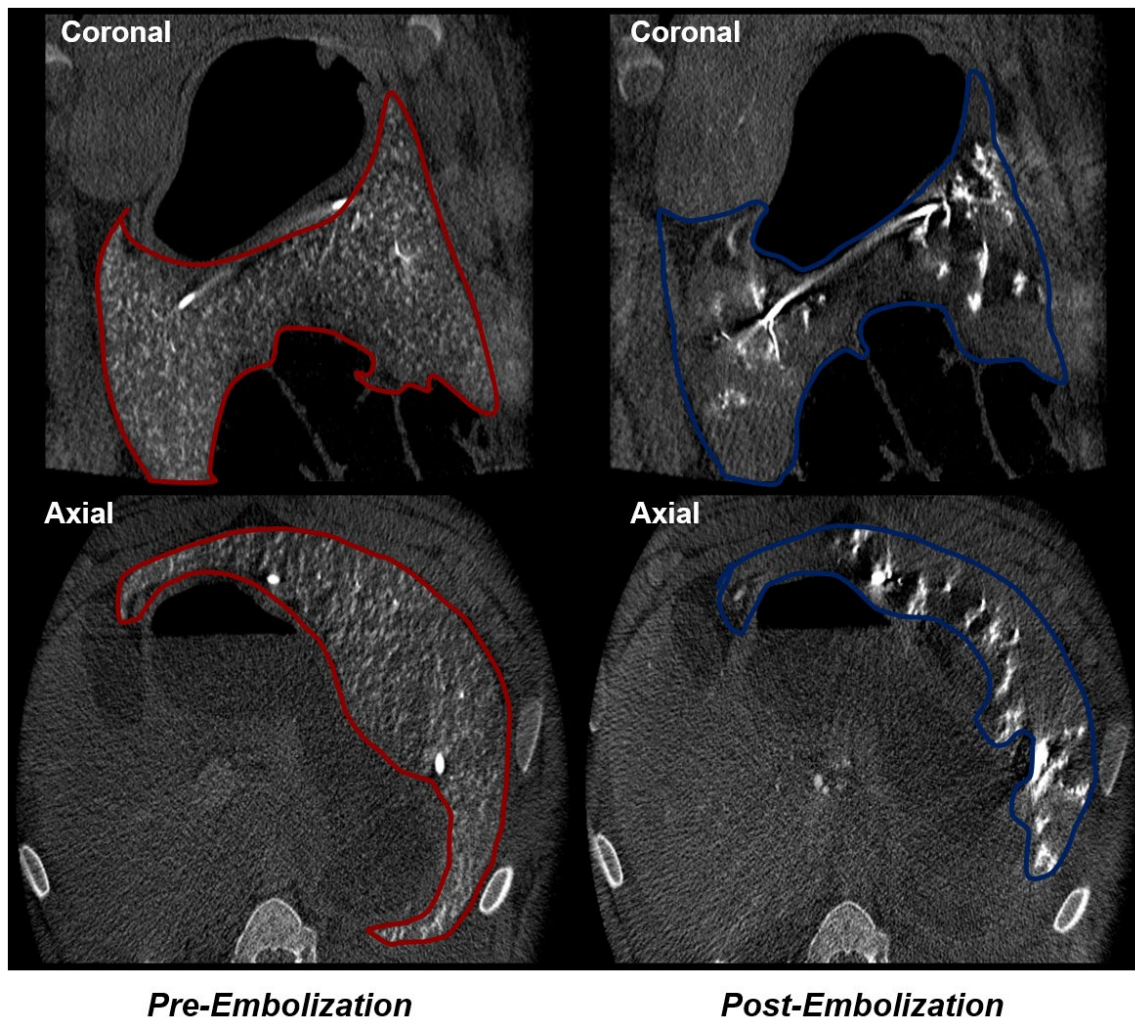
Representative Cone-Beam CTs from splenic arterial embolization
